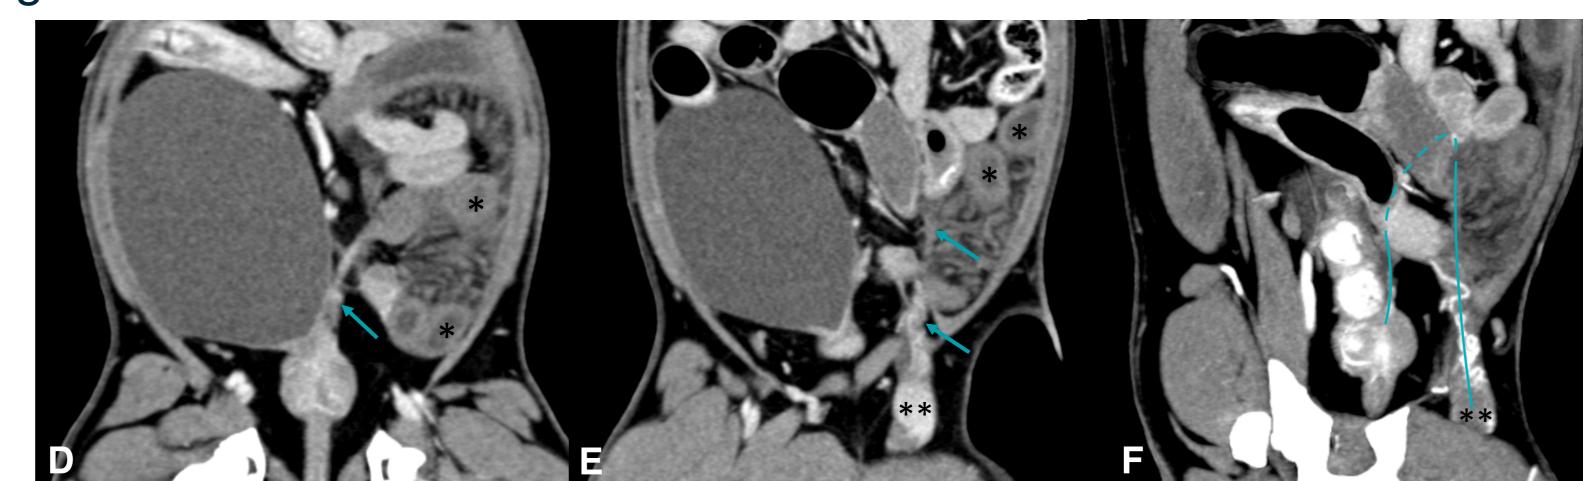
Computed tomography: sagittal (A-C) and dorsal (D-F) post-contrast images in soft tissue window (A-F) and MIP reconstruction (F). The arrows delineate the mildly to moderately thickened left ductus deferens which strangles the small intestinal loops. The blue line underlines the course of the left ductus deferens (F). (* dilated poor contrast enhancing loops,  left epididymis and testis)
